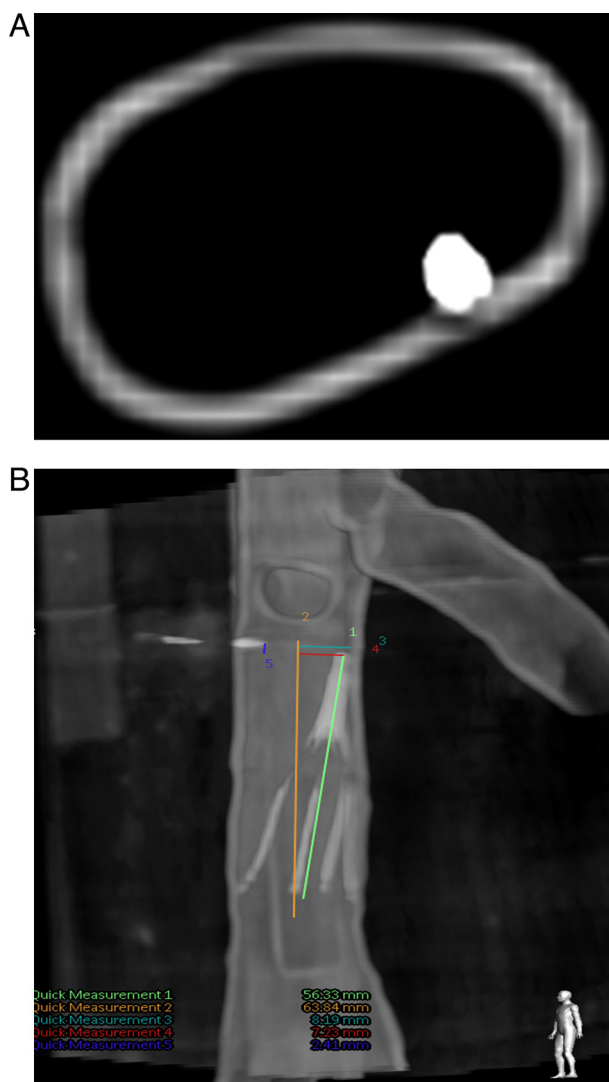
Abutment of filter tip to the IVC wall. A. Axial image of cone beam CT. B. Reconstructed image.
